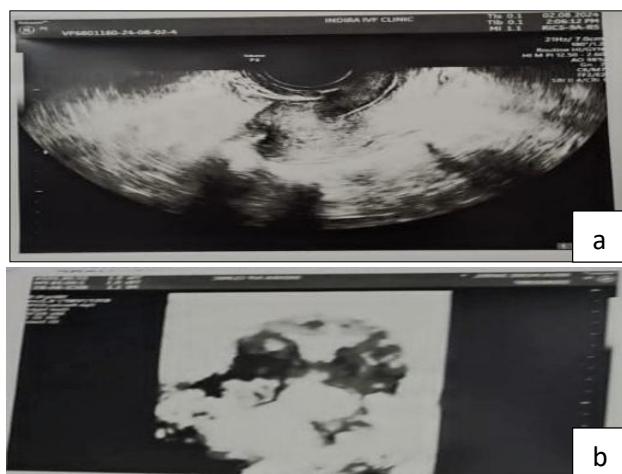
(a and b): Day-19 transvaginal 2D and 3D ultrasound showing thin (5 mm), irregular endometrium with fundal adhesions.
